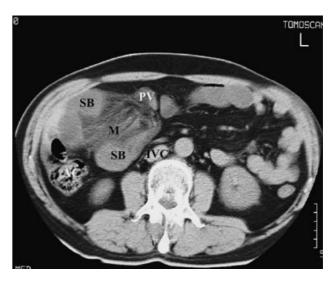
CT-scan, L1 level. Internal *SB*, small bowel, hernia through a normal orifice: the epiploic foramen (hiatus of Winslow). *M* mesentery, *IVC* inferior vena cava, *AC* ascending colon, *PV* portal vein
